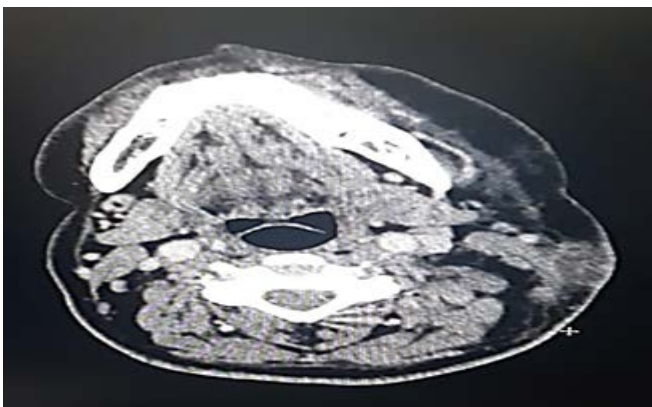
Contrast enhanced CT neck showing enlarged
